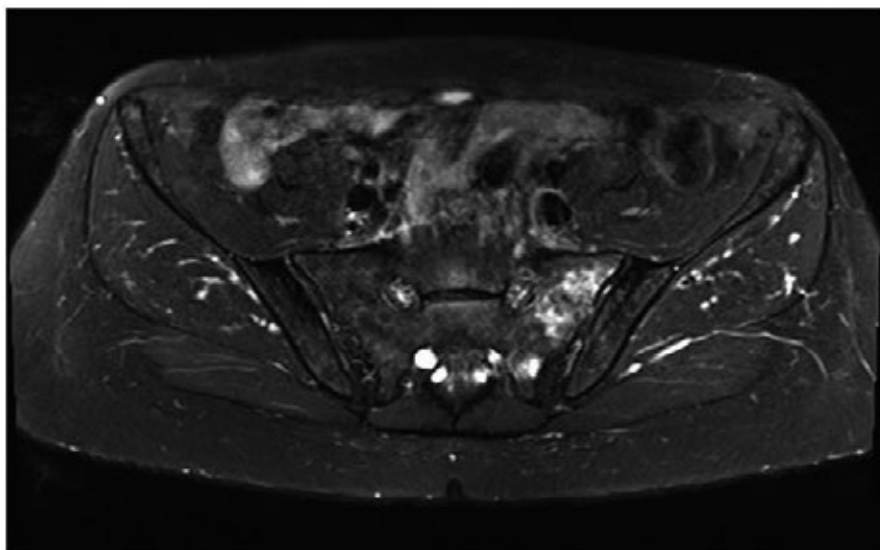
Inflammatory sacroiliitis suggestive of spondylarthritis on MRI.
